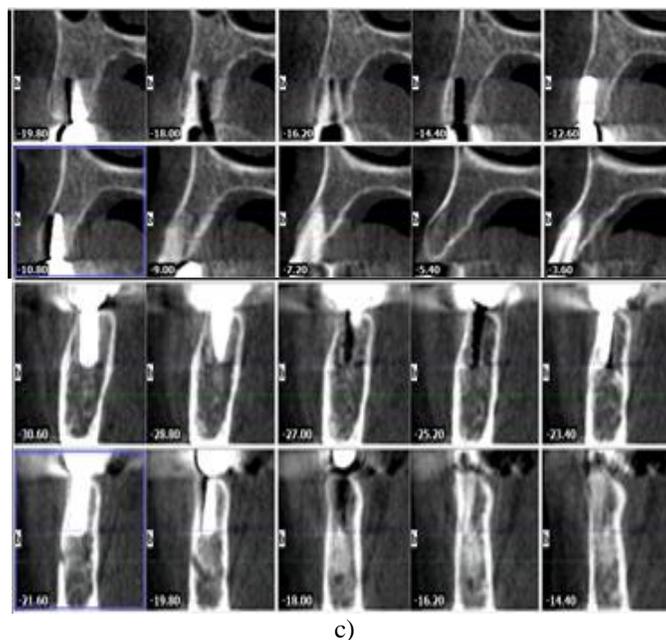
a) 1st follow up-8 months-OPG. b) Second follow up-23 months- intra oral photos, implants PA and BW radiographs. c) implants evaluation on CBCT.
